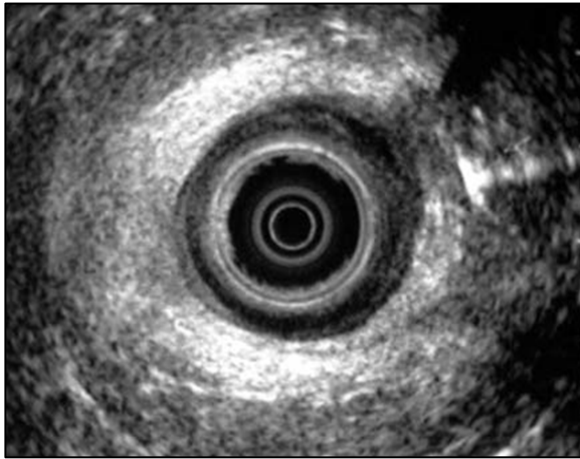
Rectal Ultrasound examination using hydrogen peroxide solution which leads to a hyper-echoic effect (upper right part of picture) showing site of fistula
